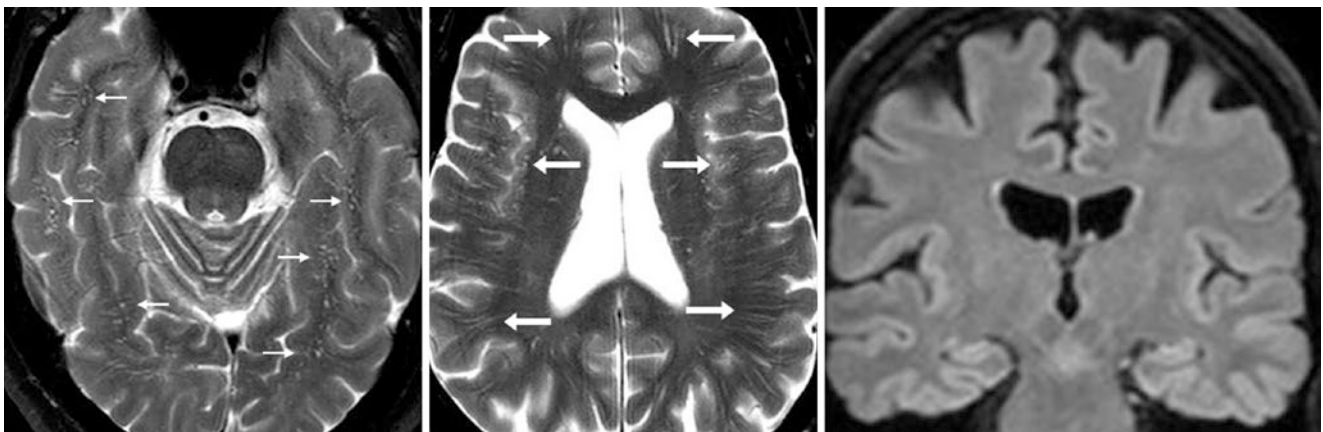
A 62 year old had innumerable slightly dilated PVSs on a 3T MRI with T2WIs (*left and middle*). The PVSs were located throughout the temporal white matter (*thin arrows, left*) and frontoparietal
